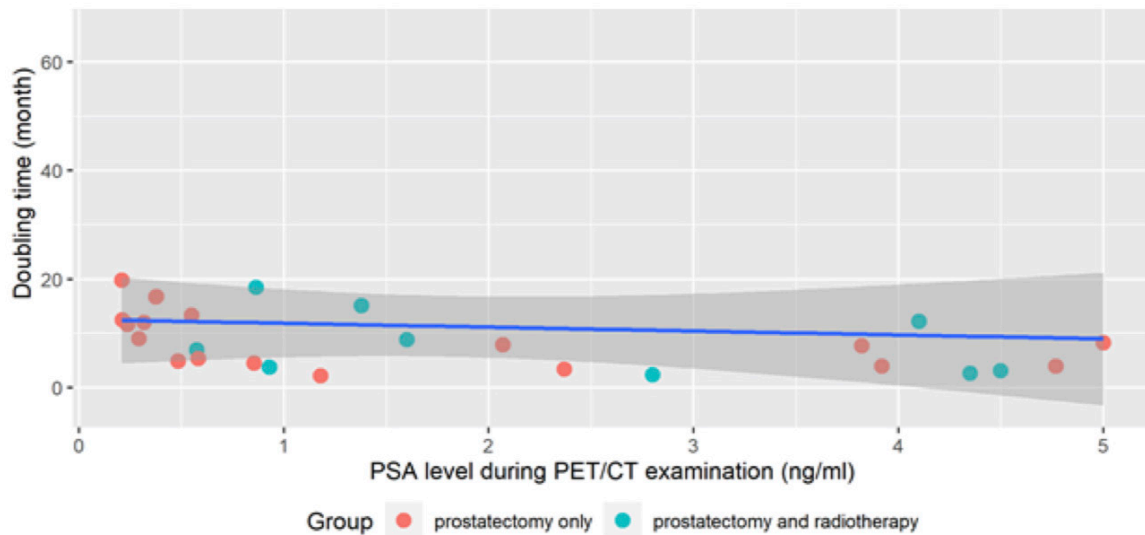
Linear regression analysis of PSA Doubling time (months) and PSA level at PET/CT examination (ng/ml).
